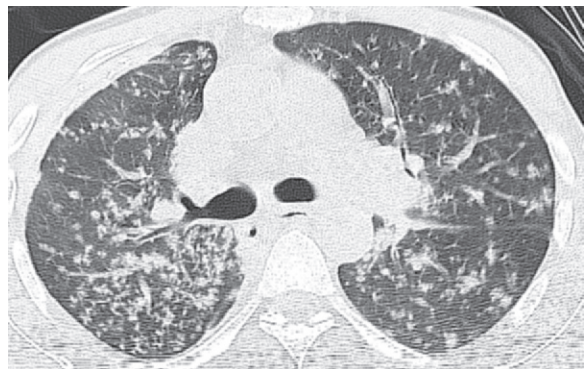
Reactivation tuberculosis in a 43-year-old man with a 2-month history of weakness, recurrent fever, night sweats, decreased appetite, weight loss, and nonproductive cough. He had a CD4 count of 34 cells/ μL and was diagnosed with HIV infection. Chest CT image shows extensive centrilobular nodules in a tree-in-bud configuration, reflecting the endobronchial spread of tuberculosis. Additional findings included mediastinal lymphadenopathy (not shown). Sputum culture grew *M tuberculosis*, with reactivation of latent tuberculosis that was attributed to the low CD4 count.
